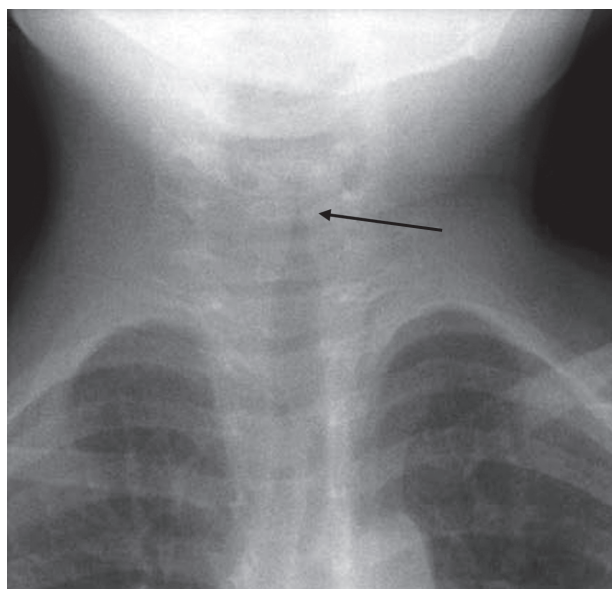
The steeple sign as seen on an AP neck X-ray of a child with croup
